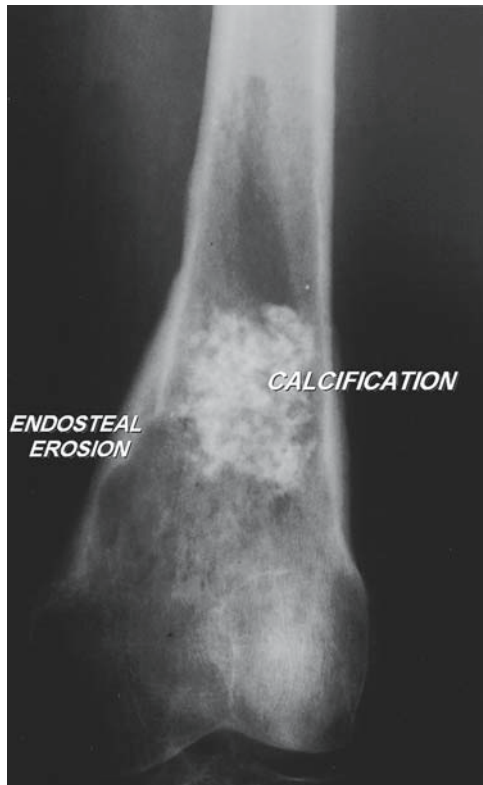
Low-grade chondrosarcoma of the distal femur. AP radiograph of a small, low-grade, well-defined central chondrosarcoma arising from the distal femur. Some endosteal scalloping is noted in this view, and some cortical thinning has occurred on the lateral side. Endosteal scalloping is typical in low-grade chondrosarcomas.
